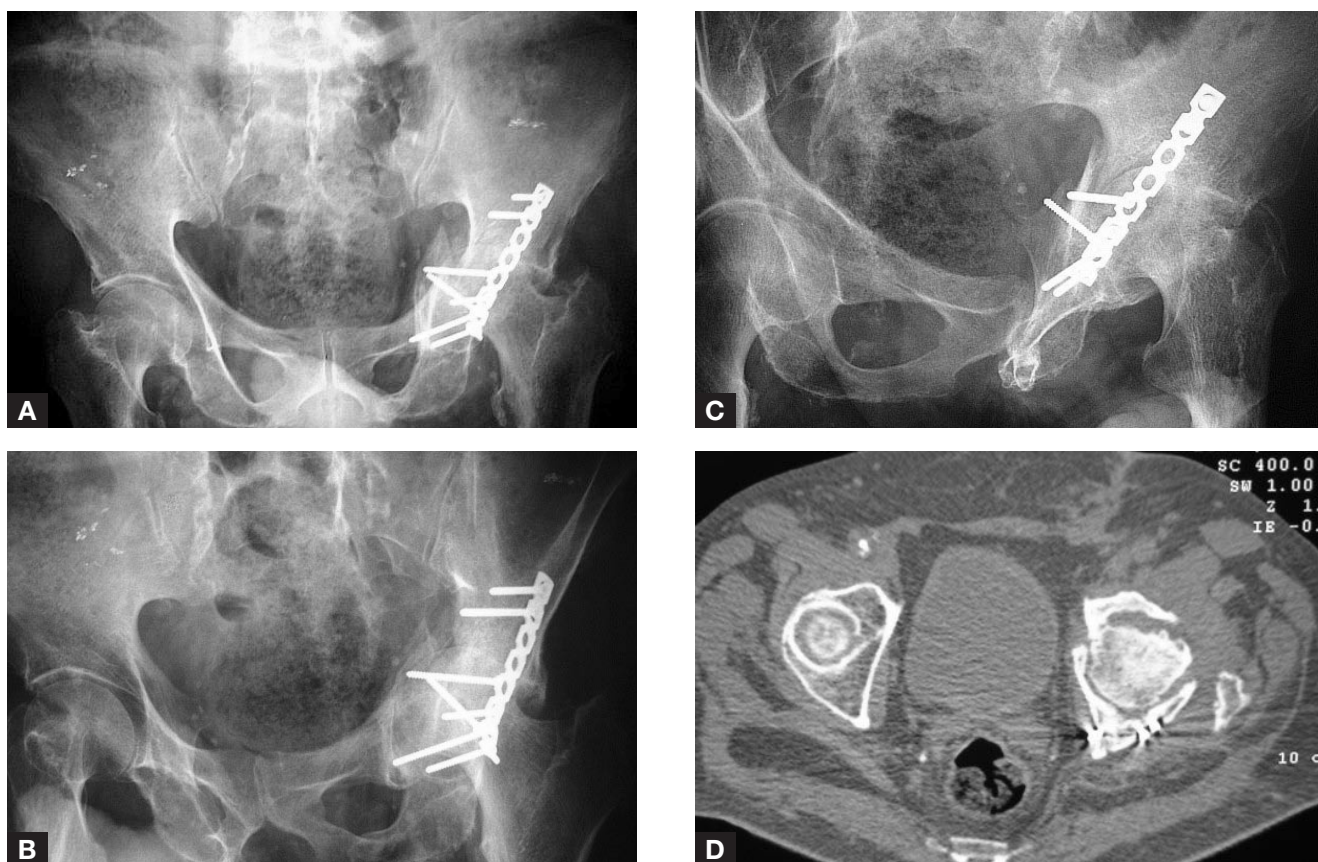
(A–C) Anteroposterior and Judet x-rays show acetabular nonunion with medial displacement of the femoral head and protrusio. (D) Computed tomography scan shows nonunion of the acetabulum and degenerative changes of the hip joint.
